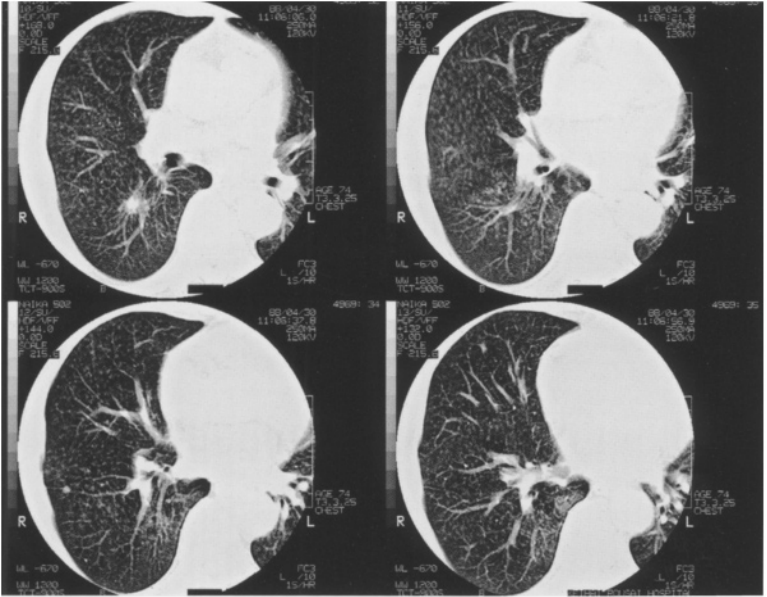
Magnified CT images of right lung show densely disseminated small nodules that are located centrilobularly
